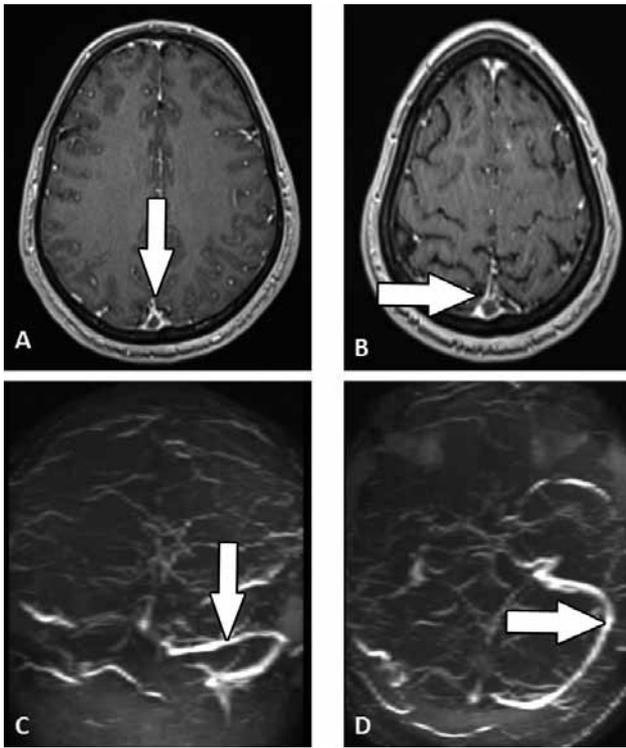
Dense triangle sign on T1-wighted MRI with gadolinium (A & B). Magnetic resonance venography showing non-visualization of superior sagittal sinus and right lateral sinus (C & D).
